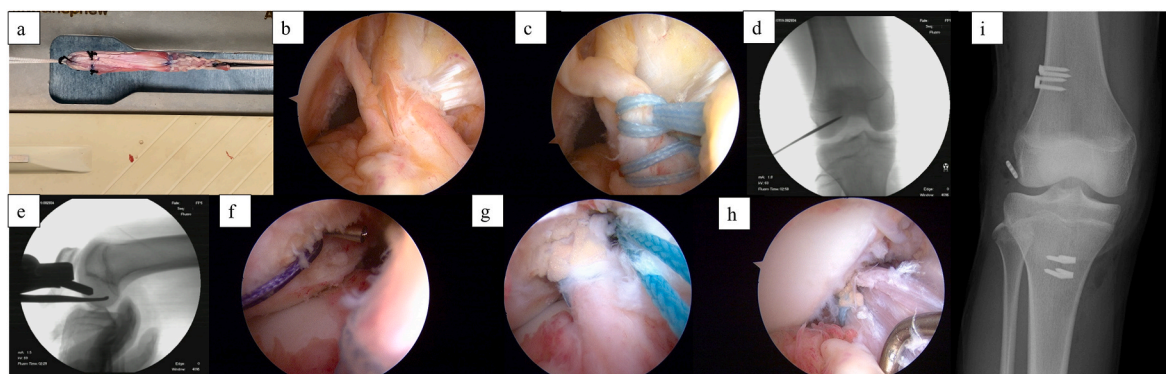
Procedure of remnant-tensioning technique for posterolateral bundle with over-the-top route procedure a. Quadrupled semitendinosus tendon strands autograft. An artificial ligament is sutured to both ends b. Anterior cruciate ligament (ACL) remnant. c. Two loops of No. 0 FiberWire® are passed into the ACL remnant. d, e. A 2.4-mm Kirchner wire is inserted into the posterolateral (PL) footprint using an outside-in guide under fluoroscopy. f. A thread is passed into the joint to guide the FiberWire® using a suture retriever. g. The remnant is guided into the hole created in the PL and fixed with manual max onto the endobutton at 30° knee flexion. h. The grafted tendon is guided from the femoral side to the tibial side i: Postoperative frontal radiograph.
